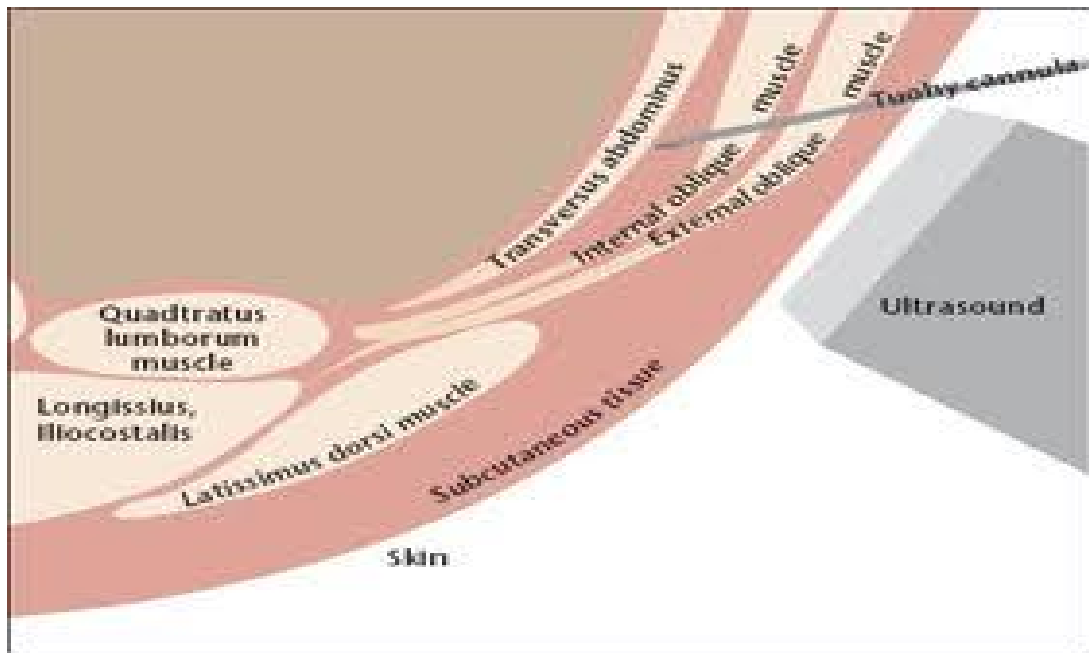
Ultrasound guided TAP block
